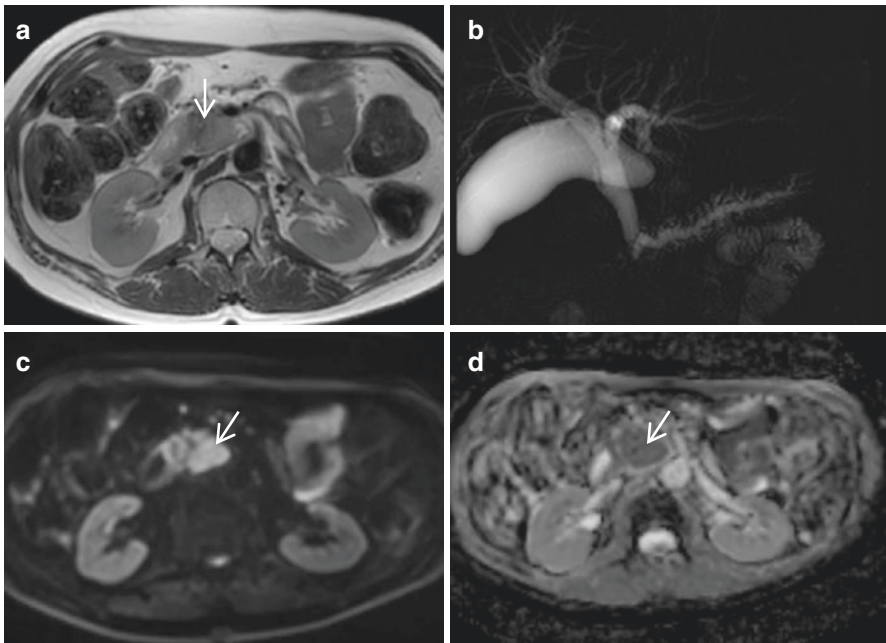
Malignant mixed-type IPMN. There is a large complex cystic lesion in the pancreatic head, as seen on T2 weighted images (a, arrow). On DWI b900 (b), there are internal septa and solid components with restricted diffusion (arrows) and corresponding low values on ADC map (c)
